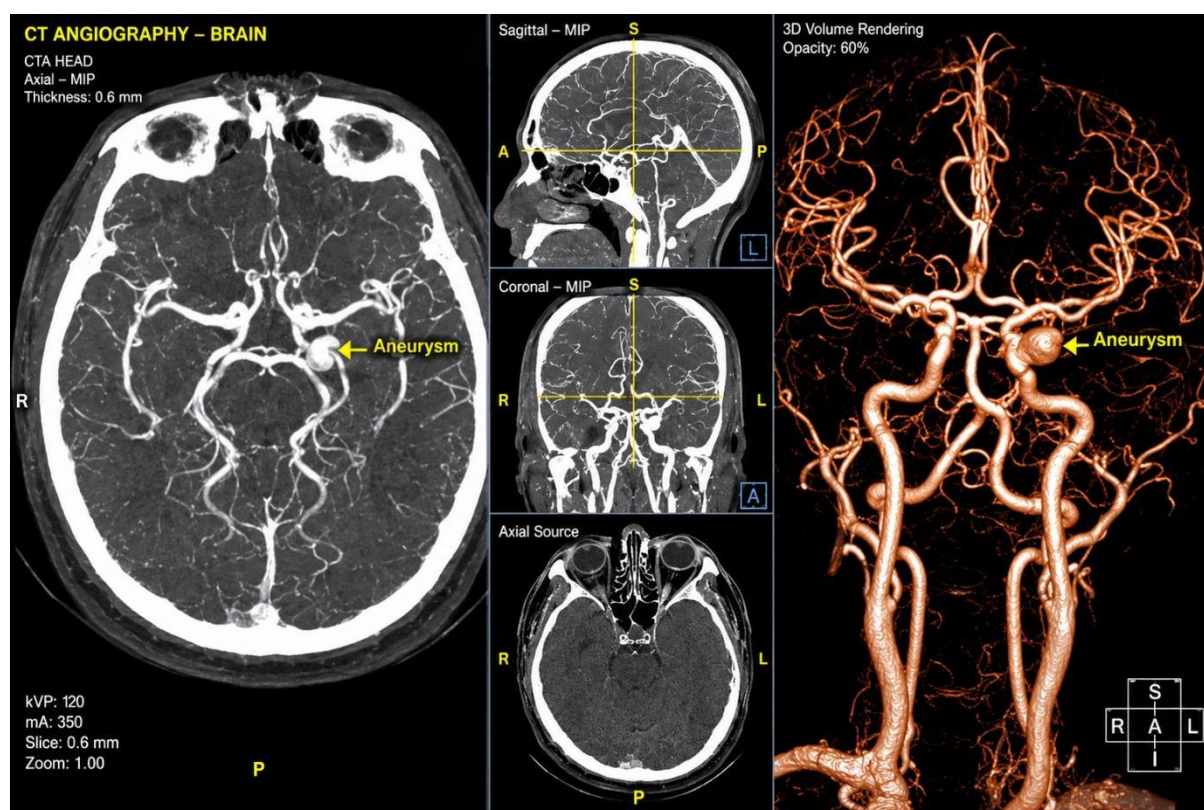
CT angiography provides high-resolution images of intracranial arteries. CTA allows detailed visualization of the cerebral vasculature, enabling detection of aneurysms and AVMs.*
